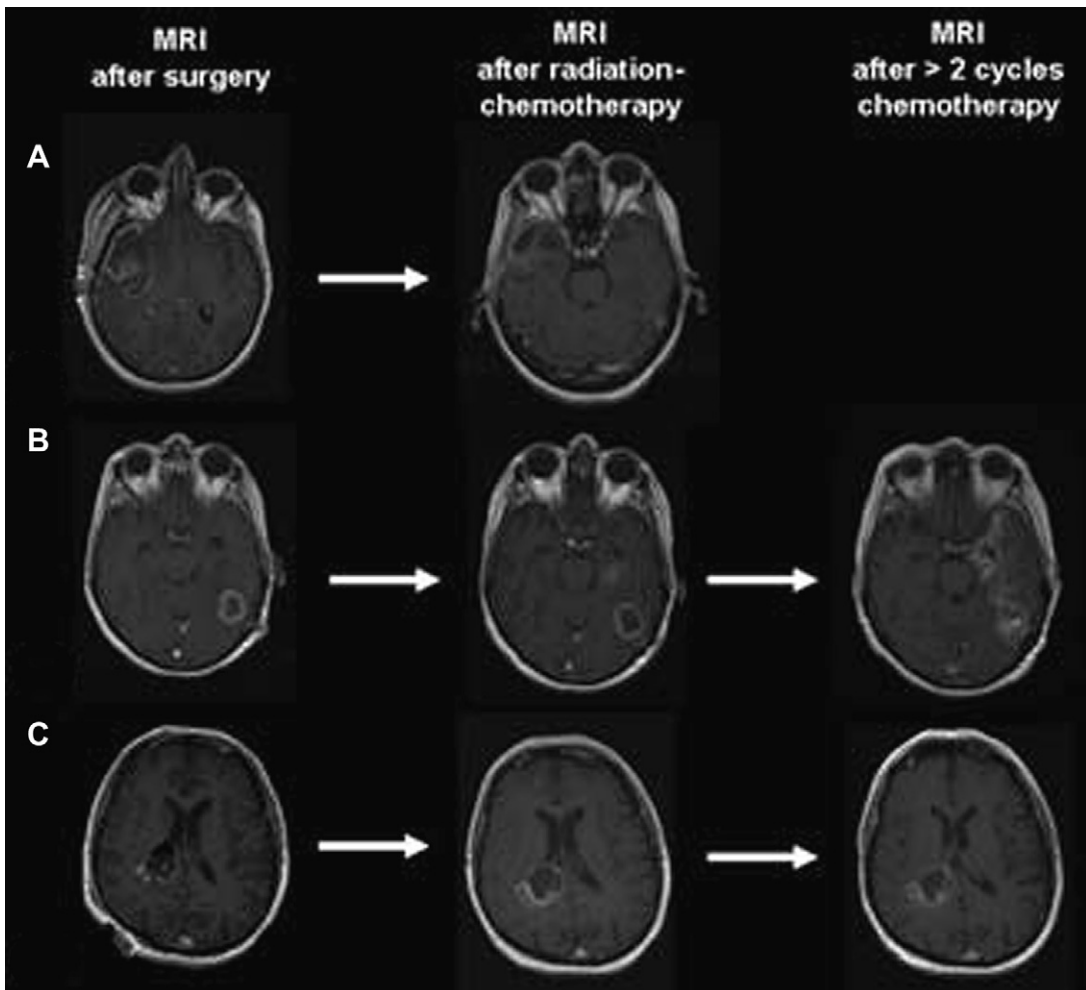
T1-weighted contrast-enhanced MRI of glioblastoma demonstrating (A) partial response, (B) disease progression, and (C) pseudoprogression. (From Roldan GB, Scott JN, McIntyre JB, et al. Population-based study of pseudoprogression after chemoradiotherapy in GBM. *Can J Neurol Sci* 2009;36:617–22; with permission.)
